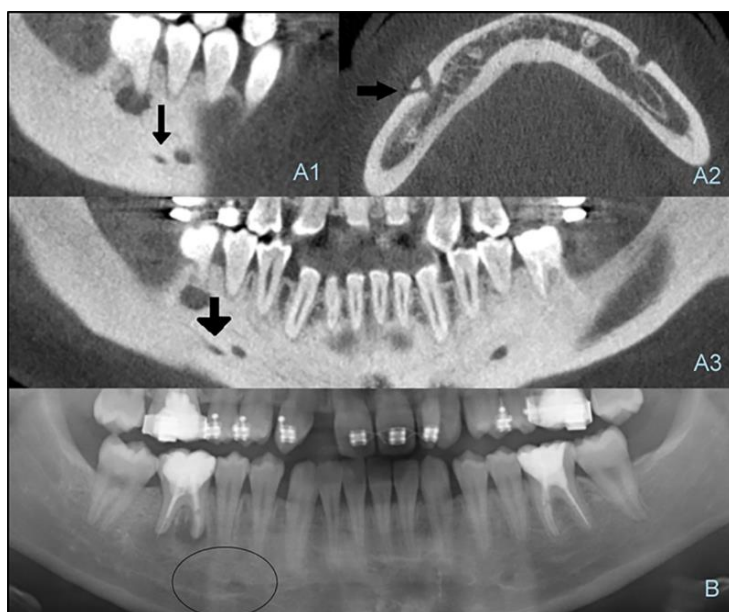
A1, A2, A3 Sagittal, axial and panoramic reconstructions of a 31 years old male patient with an accessory mental foramina located posteriorly with respect to the right mental foramen (i-CAT Vision® software). B The accessory mental foramina cannot be identified with panoramic radiography (Sidexis® neXt Generation).
